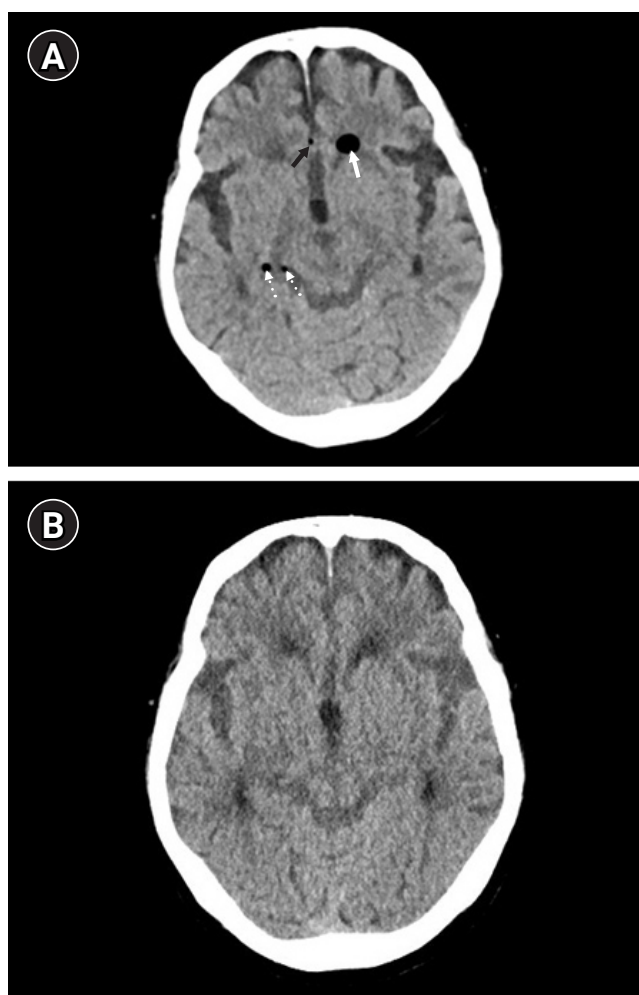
(A) Axial cranial CT scan (case 2) demonstrating air in the lateral ventricular frontal horn (white arrow), anterior interhemispheric fissure (black arrow), and right ambient cistern (white dotted arrow), and around the bilateral cavernous sinuses of the patient (case 2). (B) Follow up CT scan showed decreased pneumocephalus (next day). CT: computed tomography.
